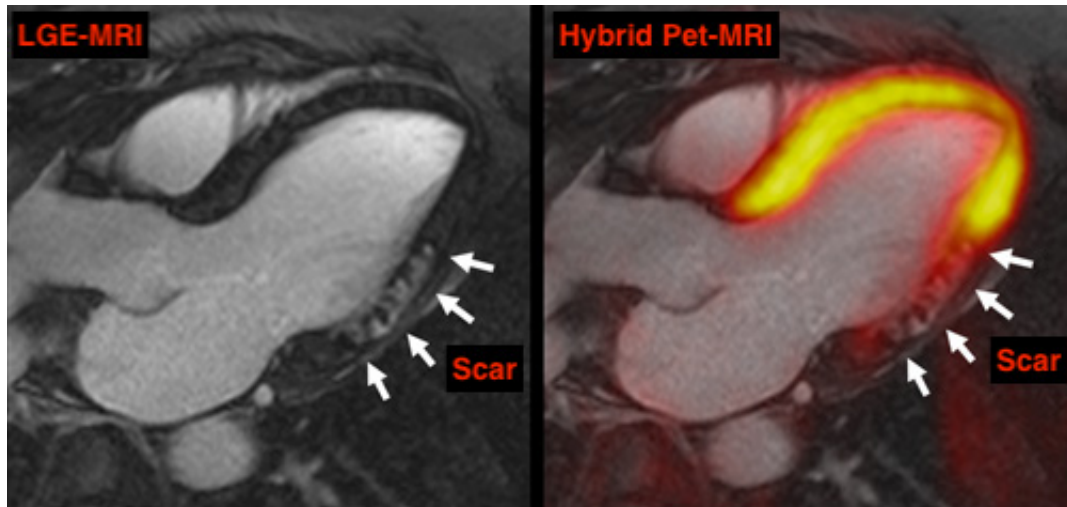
Long-axis view of the heart using hybrid PET/MR imaging which consists of an LGE-MRI and a PET images of the same patient. The scar tissue is non-viable; therefore, there is no activity seen on the PET image on the scarred region while the healthy myocardium appears bright. The image is downloaded from F. Nensa and T. Schlosser, University Hospital Essen, Germany and is downloaded from 'auntminnieurope.com' in December 2017.
